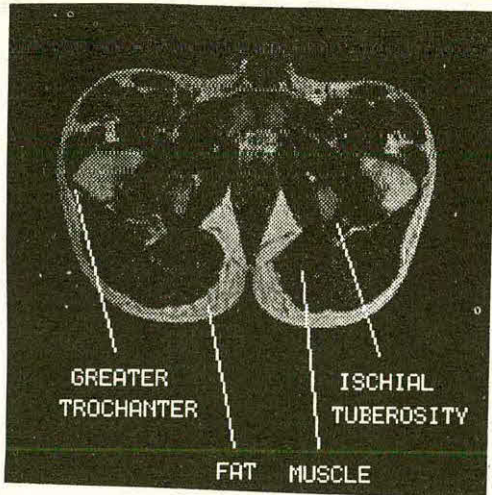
Transverse section of free-hanging buttocks generated with MRI
